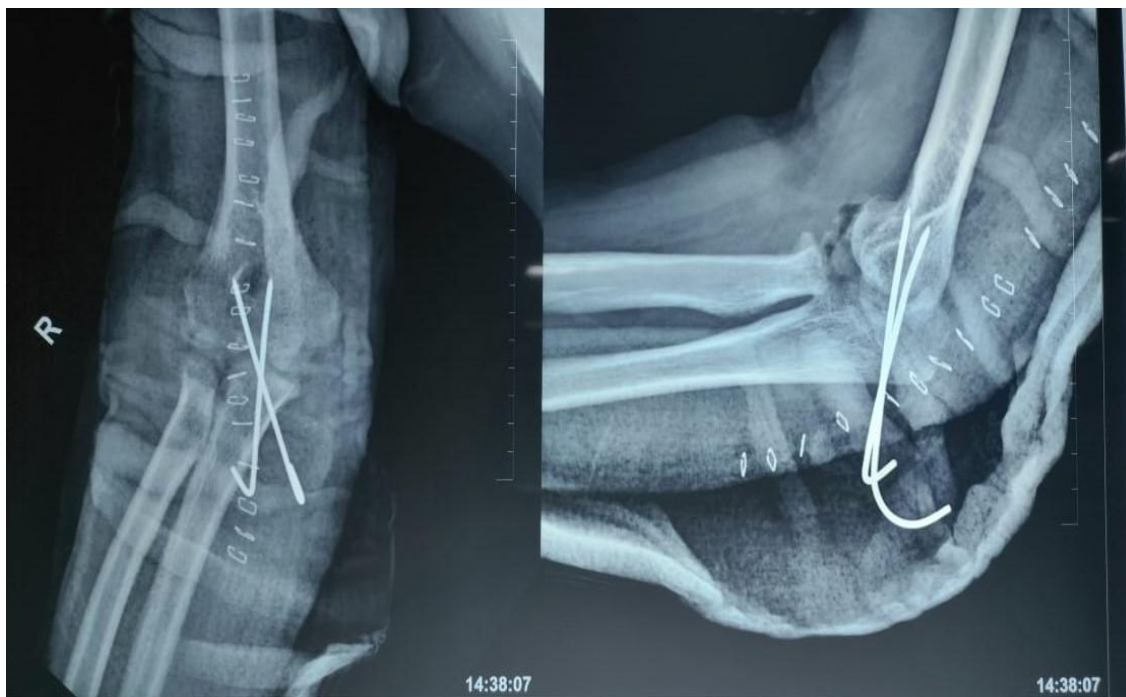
Post operative radiographs (AP & Oblique views) showing divergent 2 mm K-wires stabilized the reduced ulnohumeral articulation with excised radial head
